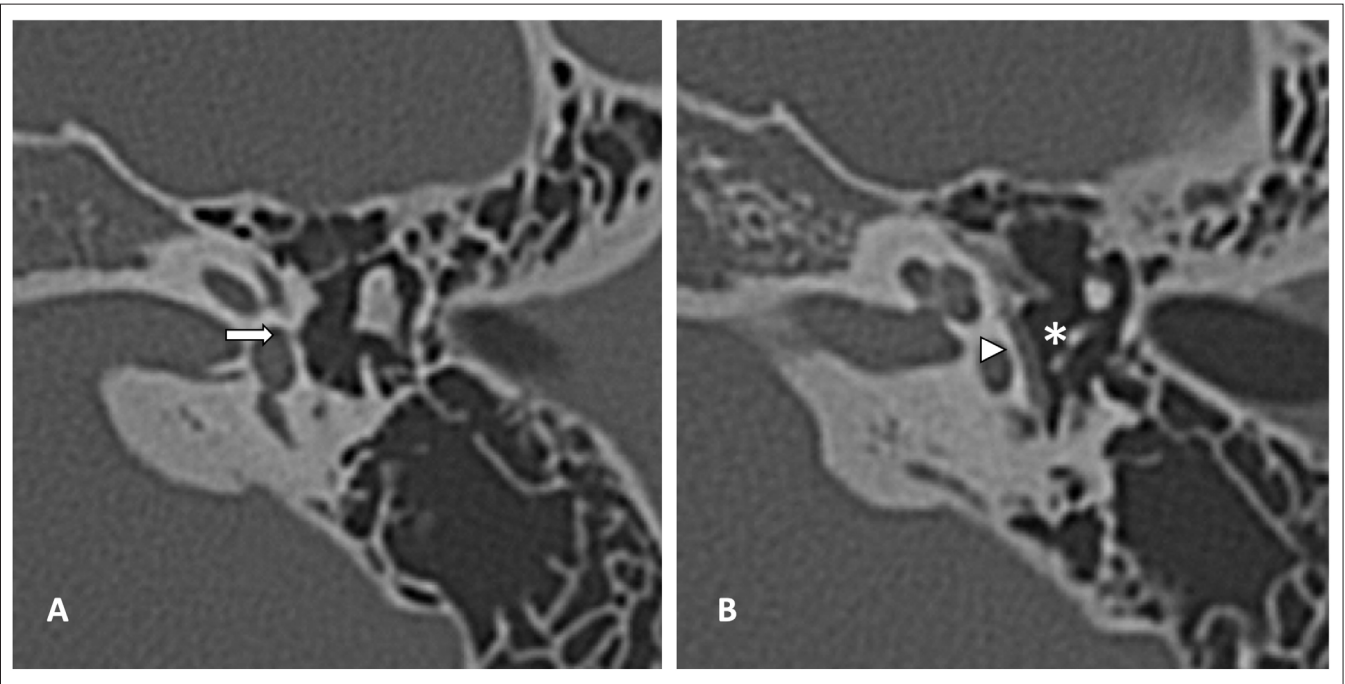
HRCT axial images of Patient D with left oval window atresia, inferiorly displaced facial nerve and dysplastic stapes. (A) Left ear: absence of the normal oval window at its expected location (arrow). (B) Left ear: inferiorly displaced facial nerve imaged on the axial section (arrowhead). Note the dysplastic stapes with floating superstructure (asterisk).
